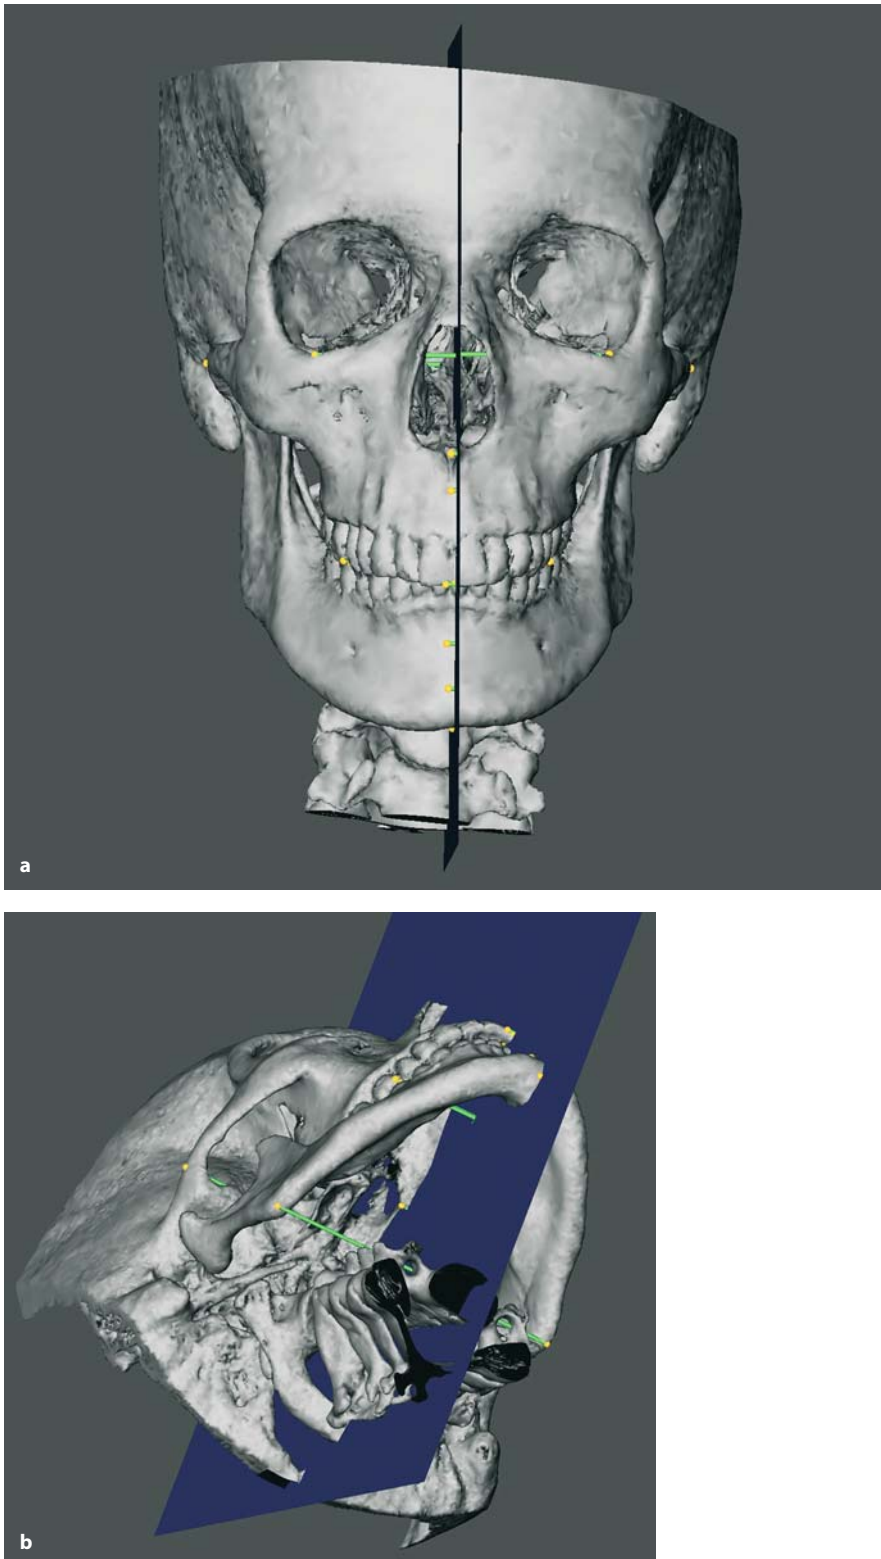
a, b. Set-up of transverse orthogonal hard tissue measurements to the median (z) plane (3-D CT, patient K.C.)
